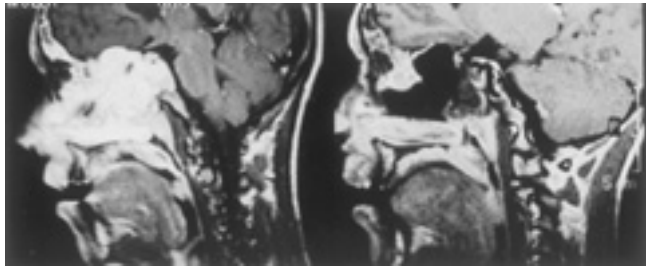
Anterior cranial fossa extension removed by the endoscopic approach. Preoperative and postoperative sagittal MRI scans are seen on the left and right, respectively (Stage II).
